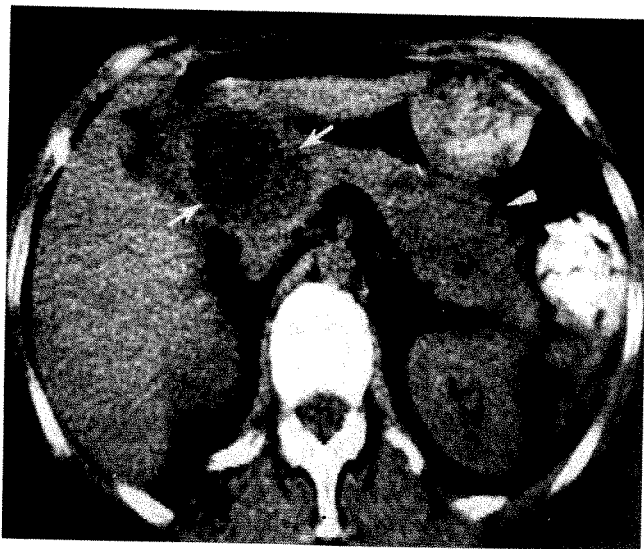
40-year-old woman with unexplained upper abdominal pain for 2 years; conventional radiographic studies normal and endoscopic retrograde pancreaticocholangiography unsuccessful. CT scan showing 6 cm low density (15 EMI units) pseudocyst within head of pancreas (arrows) with another pseudocyst of equal size within the tail (arrowhead). Second pseudocyst more clearly defined on a more cephalad scan and confirmed at surgery.
